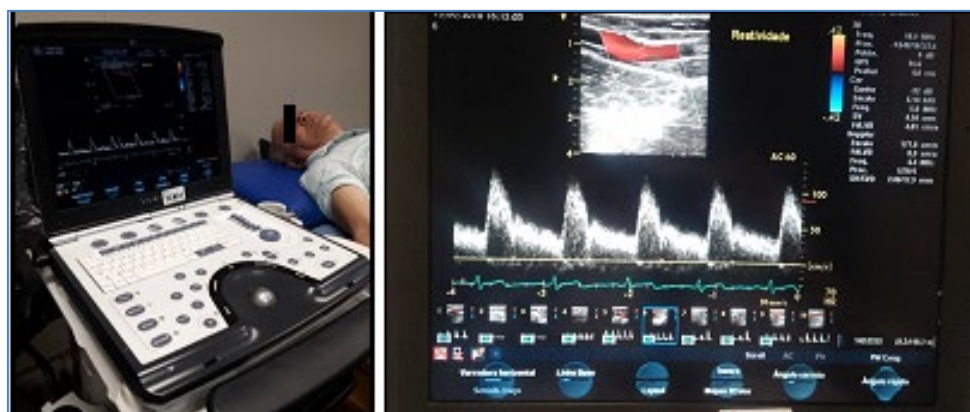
Doppler vascular ultrasound image of the brachial artery.
